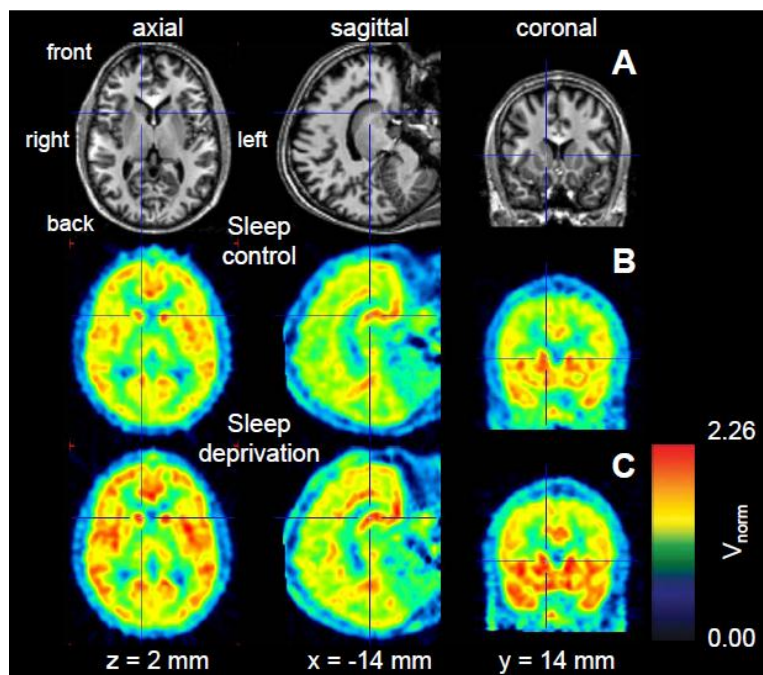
Axial, sagittal and coronal views of ^{11}C -ABP688 binding in a representative individual. (A) Magnetic resonance image (MRI) template for anatomical reference. (B) Color-coded normalized volumes of distribution (V_{norm}) of ^{11}C -ABP688 after ~ 9 hours of wakefulness (sleep control condition). (C) Color-coded V_{norm} of ^{11}C -ABP688 after ~ 33 hours of wakefulness
